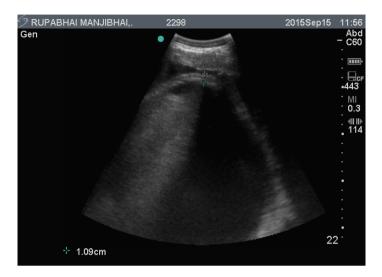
Trans-abdominal ultrasonography revealed anechoic foetal fluid, hyper-echoic uterus but no any foetal parts.
